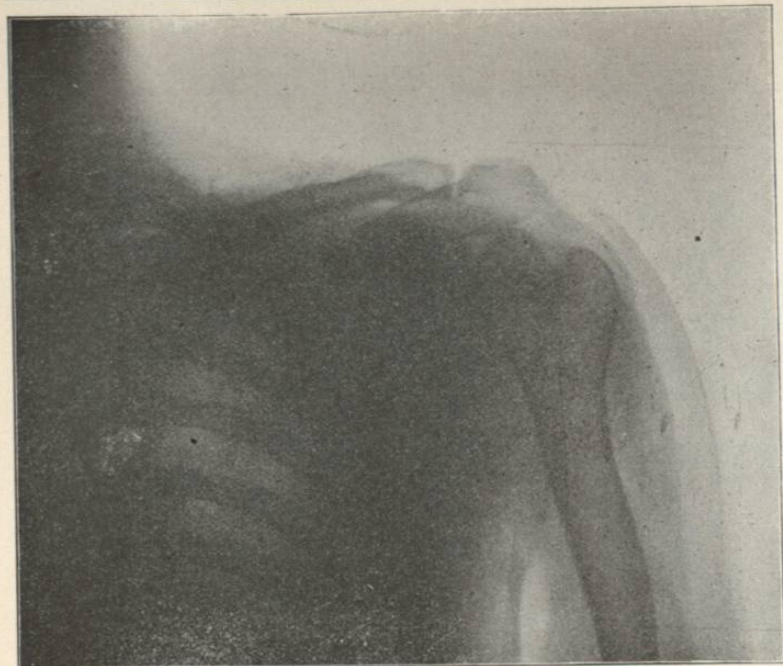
Radiograph in Case of L. E. K.—, Showing Gunshot Wound Involving the Shoulder Joint. Wound inflicted by a Mauser bullet at a distance of 6 feet. The ball passed directly through the shoulder joint, grooving the upper end of the humerus and emerging over the inner border of the scapula. Remote effects: paralysis of deltoid muscle and general weakness and impaired nutrition of the arm.
